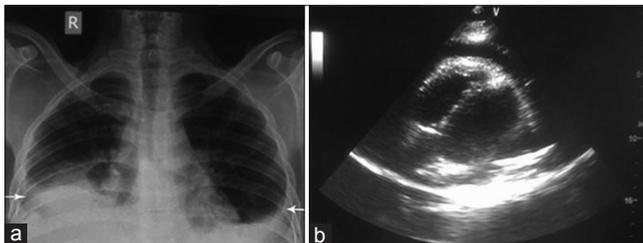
(a) Chest radiograph showing cardiomegaly with bilateral pleural effusion. (b) Echocardiogram (apical view) showing pericardial effusion
